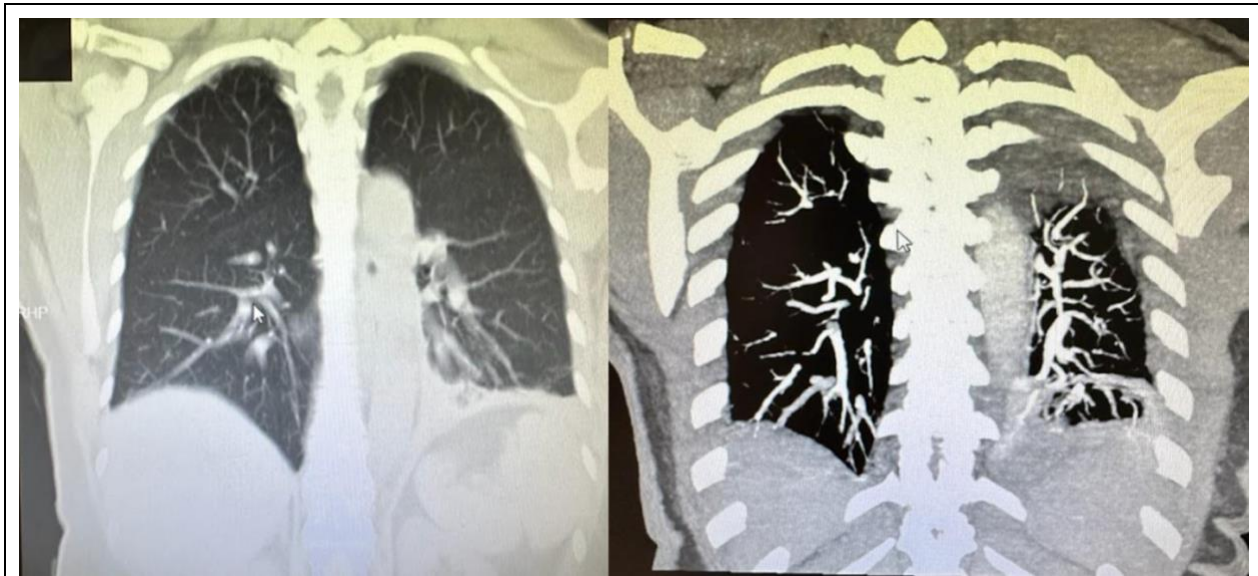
Computed tomography pulmonary angiography showing filling failure in segmental arterial branches to both lower lung lobes.
